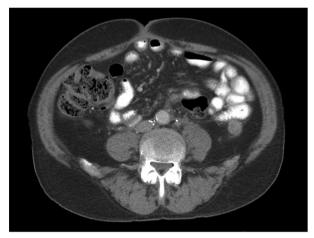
Computed tomography of abdomen and pelvis with contrast showing a heterogenous solid-appearing mass in the left abdominal mesentery measuring 5.2×3.7 cm.
